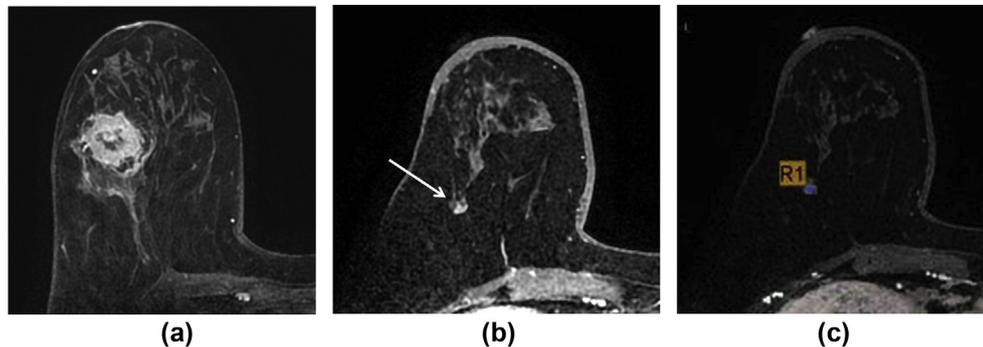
Screening breast MRI images of 54-year-old woman with a personal history of ipsilateral breast cancer. (a) The patient underwent right breast-conserving surgery for newly diagnosed breast cancer in right breast 10 o'clock direction. (b) After 2 years, early contrast-enhanced axial image shows a 0.7 cm irregular enhancing lesion in right breast 8 o'clock direction (arrow). Reader 1 interpreted this lesion as category 4b and reader 2 as category 4a. (c) On the same image with CAD, the lesion shows delayed persistent enhancement pattern. Both readers changed the diagnosis to category 3. This lesion has shown no interval change for 3 years and is considered a benign lesion.
